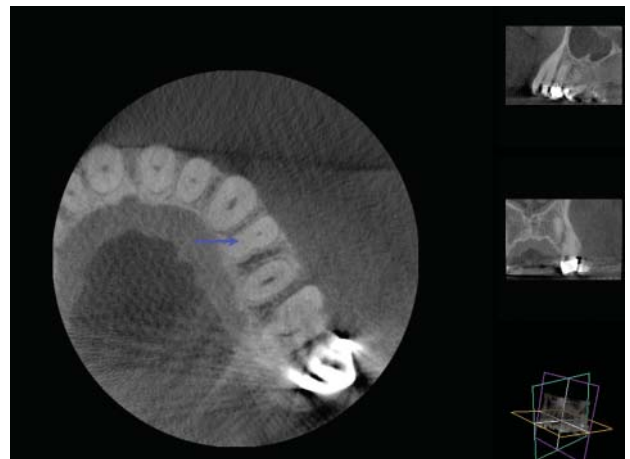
The CBCT shows that the palatal canal (see arrow) is located 1 mm apical (and slightly mesial) to the last marker.
